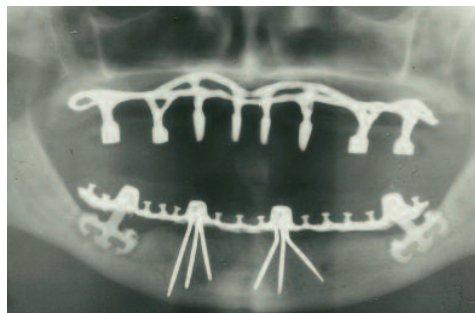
Panoramic radiograph of historic dental implants
